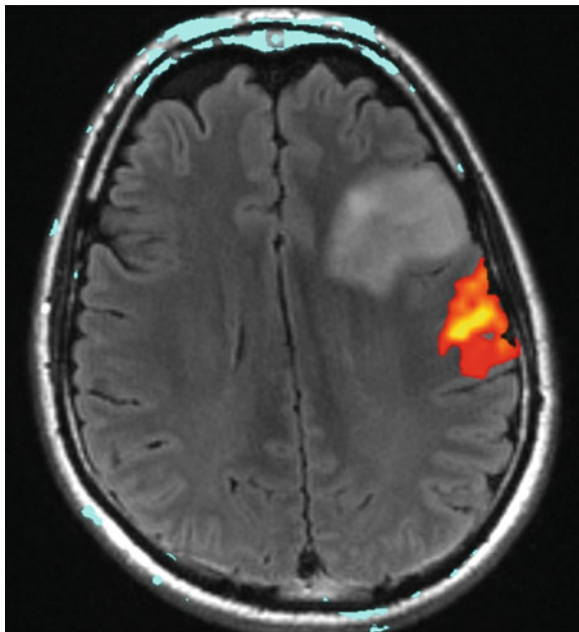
Axial turbo fluid attenuated inversion recovery (FLAIR) scan demonstrating the area of superimposed brain activation immediately posterior to the area of increased signal that was found to be a low grade oligodendroglioma on pathological examination. The task being performed on the blood oxygen level dependent (BOLD) study was tongue tapping
